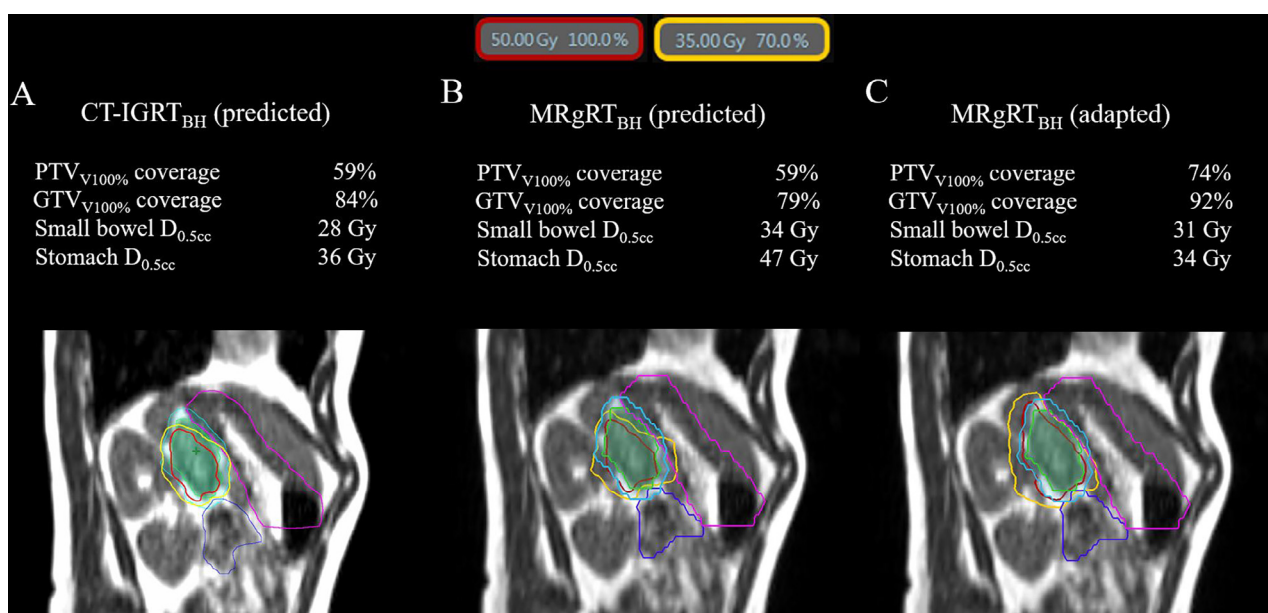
Example of the indication for online adaptation quantified by recalculating the initial plan on the anatomy of the day, displayed for CT-IGRT_{BH} (A) and MRgRT_{BH} (B) for a single treatment fraction, in addition to the clinical online adaptive MRgRT_{BH} plan (C) created and delivered for this fraction. Note: CT based image-guided radiotherapy with breath-hold (CT-IGRT_{BH}), MR-guided radiotherapy with breath-hold (MRgRT_{BH}), relative volume of the target covered by 100% of the prescription dose (V100%), maximum dose to 0.5 cc of the organ-at-risk (D0.05 cc), Gray (Gy).
